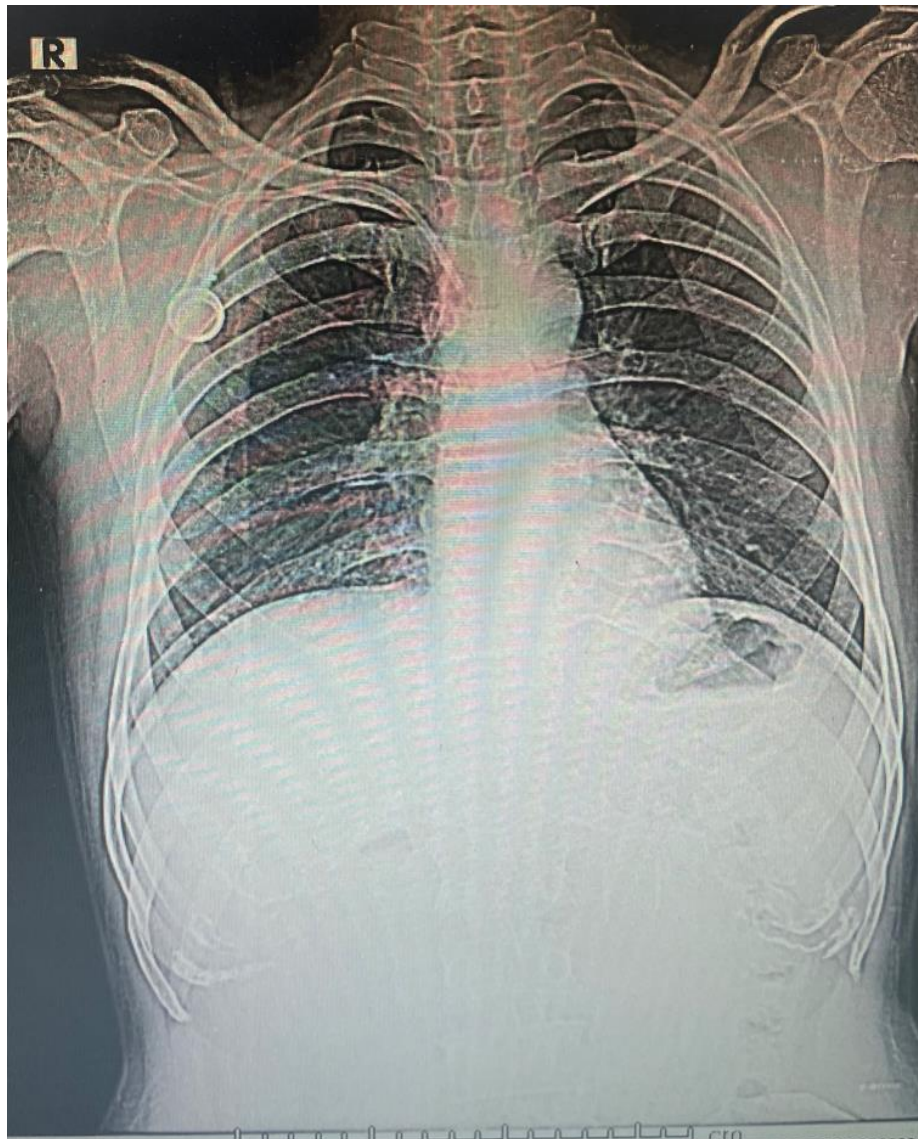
Chest radiograph demonstrating an implanted subclavian venous access device and catheter.
